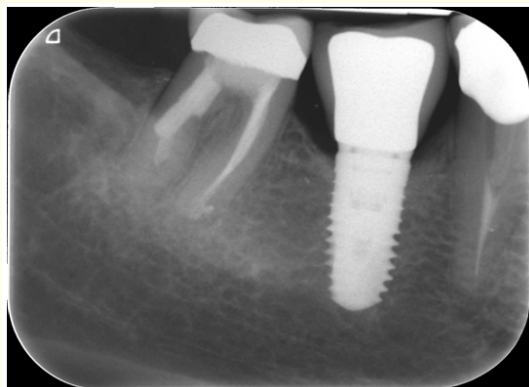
Periapical x ray of control after 11 years of function.
